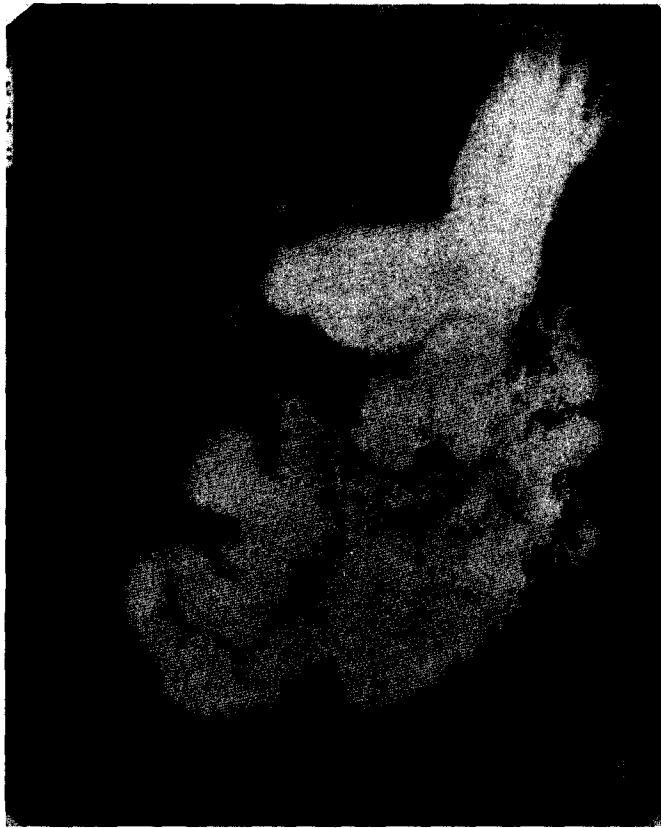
Case XI. Roentgenogram showing the communication between the stomach and the transverse colon. Film was taken about ten minutes after ingestion of barium. Note the extensive filling of the small bowel. At fluoroscopy a loop of jejunum was easily visualized between the stomach and the colon.
